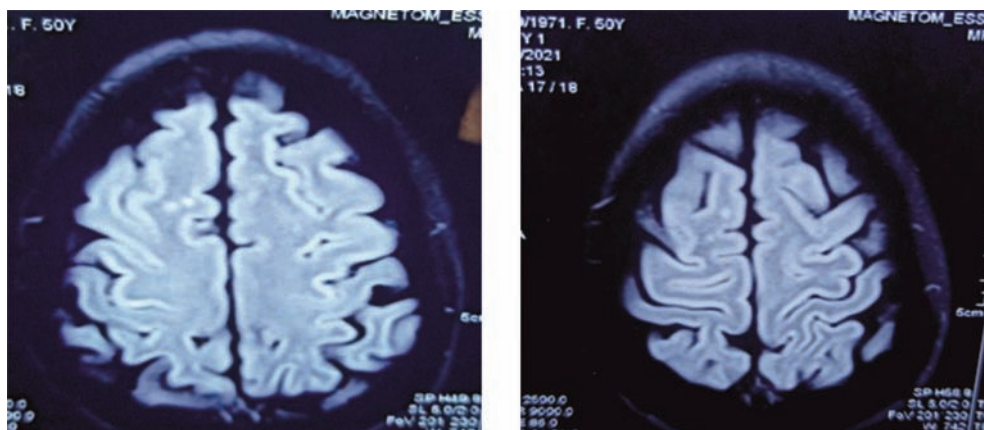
MRI Brain (FLAIR) showing cortical ribbon pattern in bilateral cortical areas
